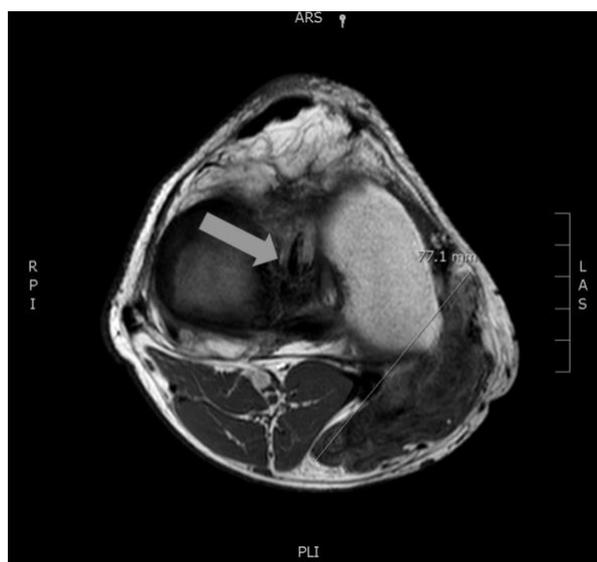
Axial MRI (T1-weighted, with contrast enhancement), showing the pre-operative extra-articular mass on the posteromedial side of the knee, with a maximum diameter of 7.5cm. Note (arrow) the same low signal changes of the ACL graft in the intercondylar region. (October 2015).
